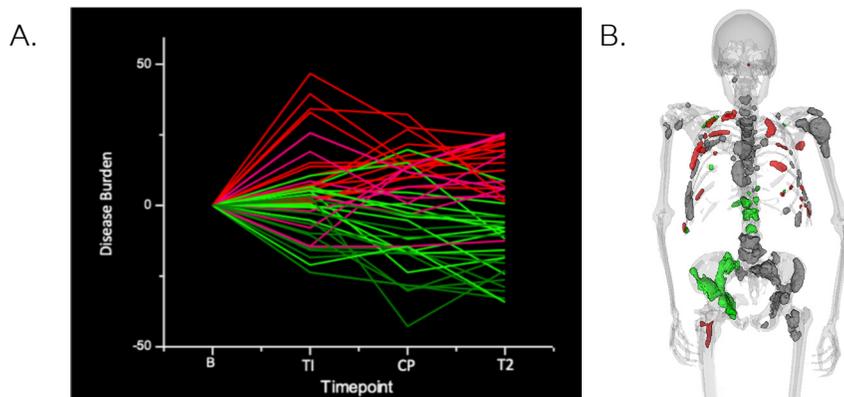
(A) The graph represents the quantitative response metrics at different times for every lesion based on changes in SUV_{total} (Disease Burden). Each line represents a lesion at Baseline (B), Time 1 (T1), Clinical Progression (CP), and Time 2 (T2). (B) The image on the right, represents the precise location of the lesions in the right graph, combined with the response status for each lesion.
